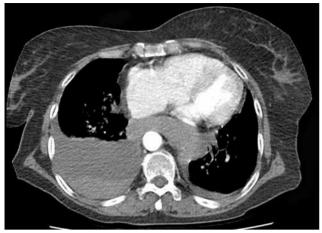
Computed tomography of chest reveals a right side pleural effusion and mediastinal hematoma.
